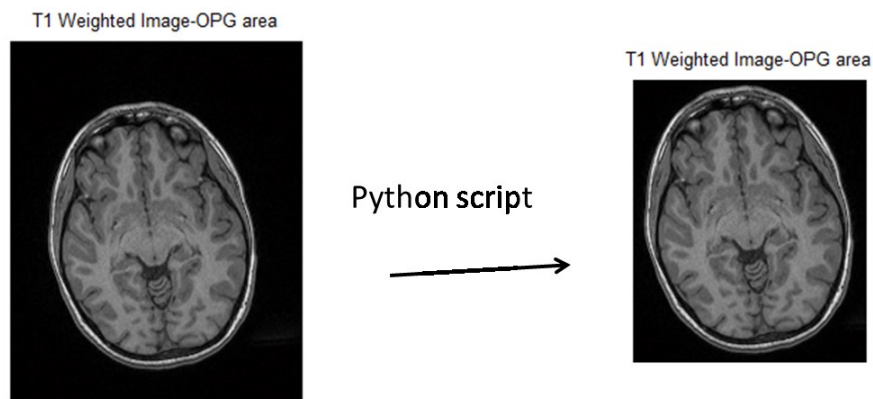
Reduction in the Field of View of the anatomical 1.5T MRI image
